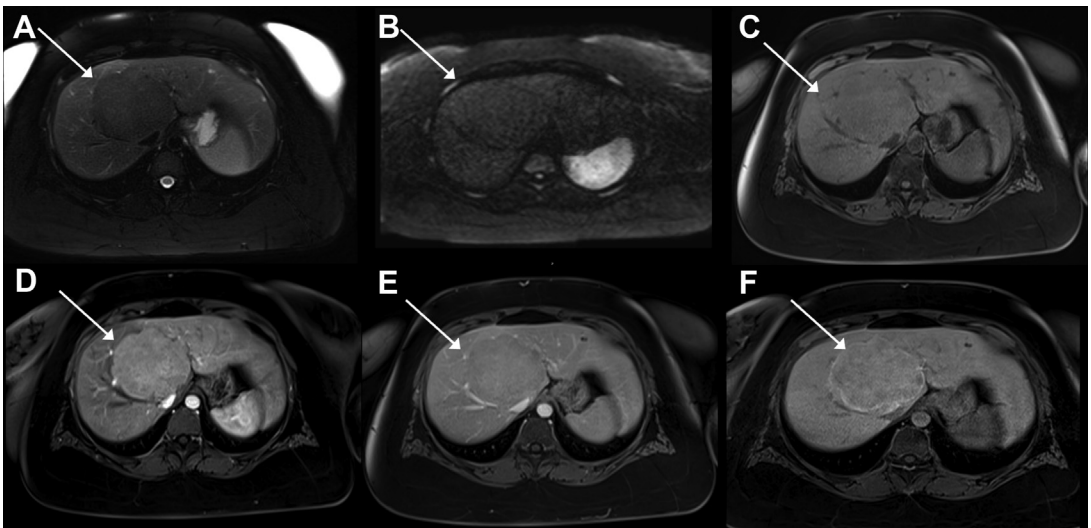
β -Catenin-activated adenoma hyperintensity in the hepatobiliary phase. Large lesion hypointense on fat-saturated T2-weighted fat saturated image (A), without diffusion restriction (B), isointense on T1-weighted fat-saturated image (C), with arterial hyperenhancement after injection of gadobenate dimeglumine (0.1 mL/kg) (D) and no washout in the delayed phase (E). In the hepatobiliary phase (F), the lesion demonstrated hyperintensity consistent with a true increased uptake of gadobenate dimeglumine (0.1 mL/kg).
